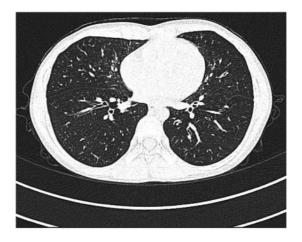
HRCT chest of a child with ABPA showing early central bronchiectasis.
